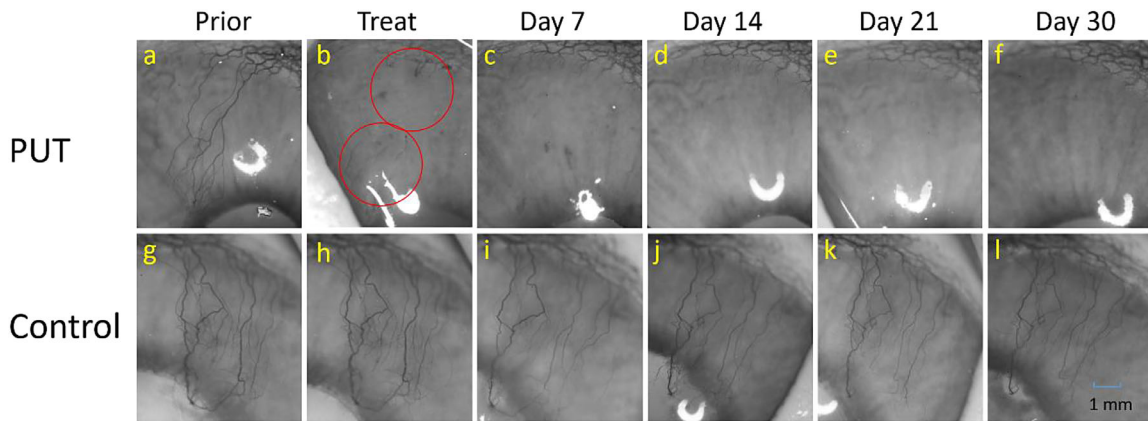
Red-free photographs of rabbit CNV before and after PUT treatment in comparison with results from the control group at the same time points. (a–f) Red-free photographs of one case in the PUT treatment group. The *red circles*, which have a diameter of 3 mm, indicate the treatment areas (b). The applied ultrasound pressure was 0.43 MPa at 0.5 MHz, the applied laser fluence was 27 mJ/cm² at 1064 nm, and the treatment duration in each *red circle* was 10 minutes. (g–l) Red-free photographs of one case in the control group. Prior, 1 day before the treatment (1 week after suture removal); Treat, immediately after treatment.
